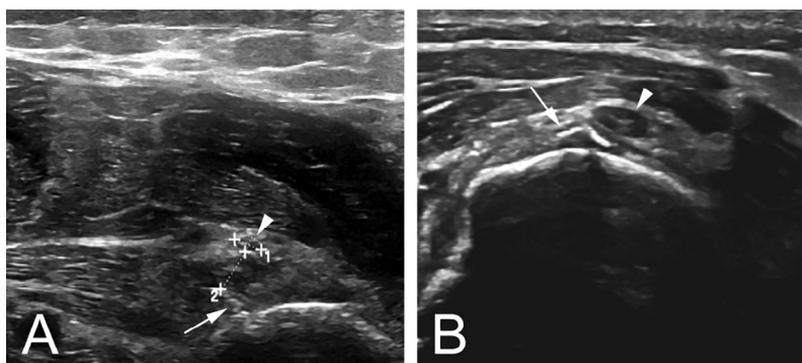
(A) High-resolution ultrasound shows close proximity of the radial nerve (◄) to an osteosynthesis screw (→) with distance measurement between the 2 structures. (B) Radial nerve (◄) with adjacent bone fragment (→).
